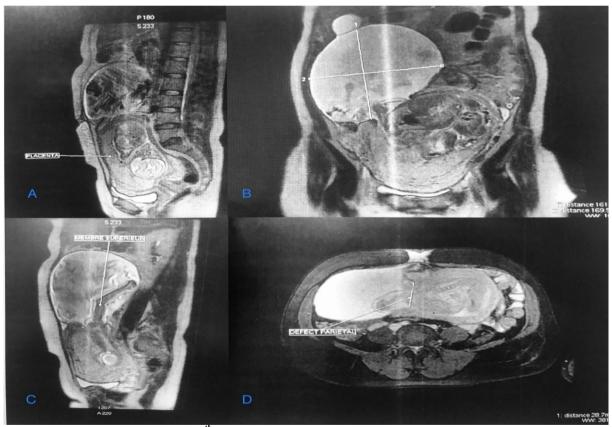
Abdominal-pelvic MRI at 22th weeks of gestation showing
